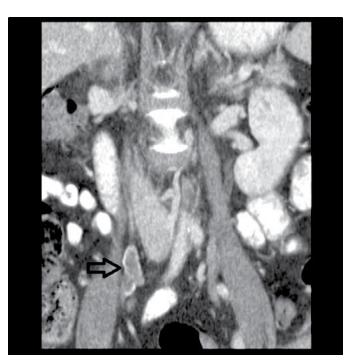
Coronal abdominal computed tomography scan showing evidence of thrombosis and enlargement of the distal end of the right ovarian vein (arrow).
